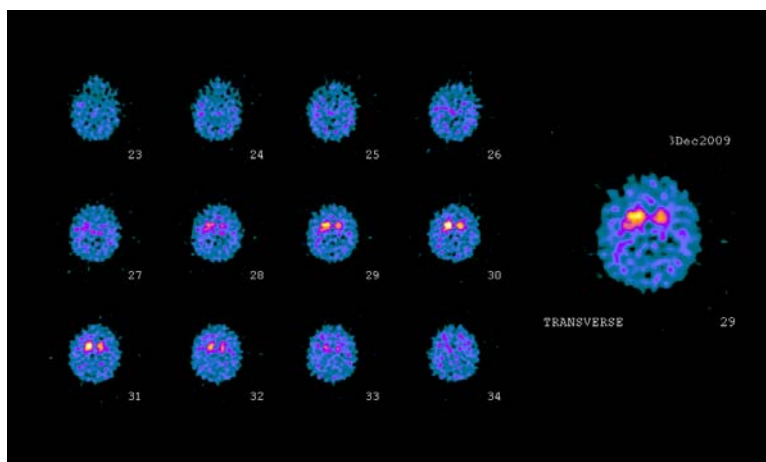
¹²³I-FP-CIT SPECT interpreted as moderate presynaptic dopaminergic deficit in patient with Parkinson's disease (clinical stage 2.0 H&Y)
